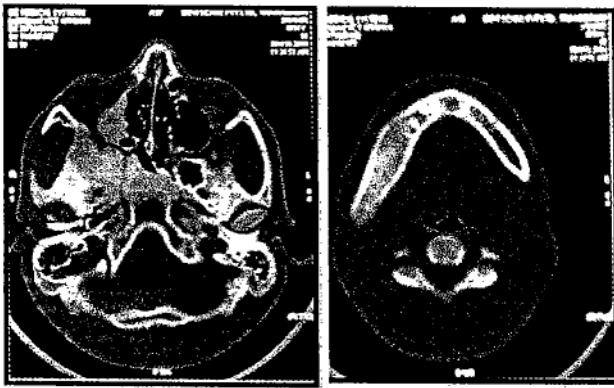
Axial CT showing involvement of maxilla, maxillary sinus, sphenoid bone and mandible
